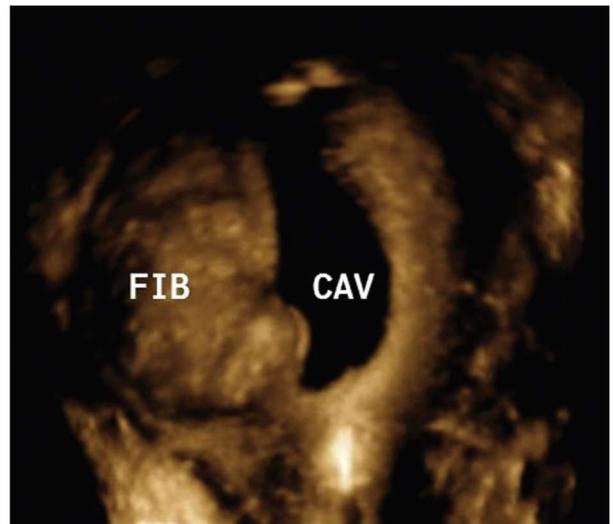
Saline infusion sonography demonstrating a 34×35 mm intramural fibroid distorting the cavity.
